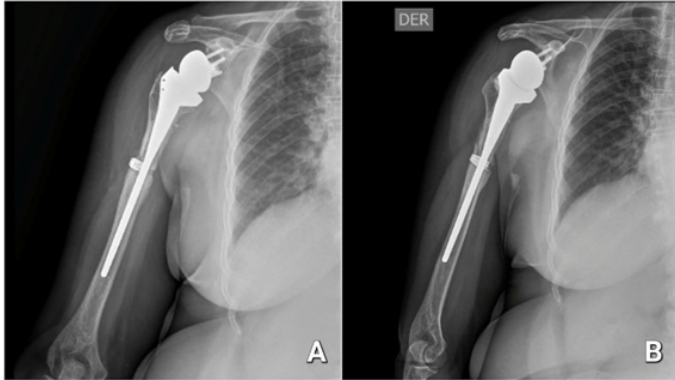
anteroposterior control radiograph of the right shoulder at five months postoperatively in proper position. A. Front. B. External rotation.
